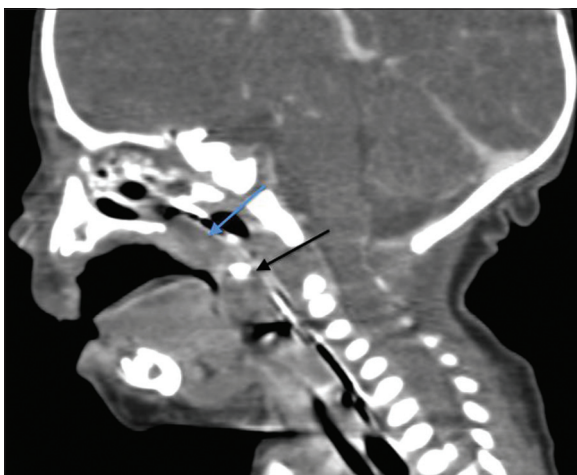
Sagittal reconstruction of a post-contrast computed tomography, which shows a lesion in the posterior wall of oropharynx (blue arrow) with focus of calcification (black arrow) causing significant compression of the airway
